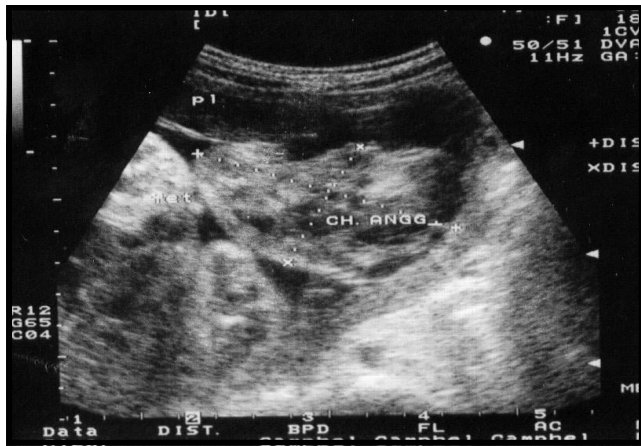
Ultrasound showing hyperechogenic chorioangioma located at placental margin, the tumour was avascular on color doppler imaging. PL=placenta, CH ANGO=chorioangioma (case 1).
